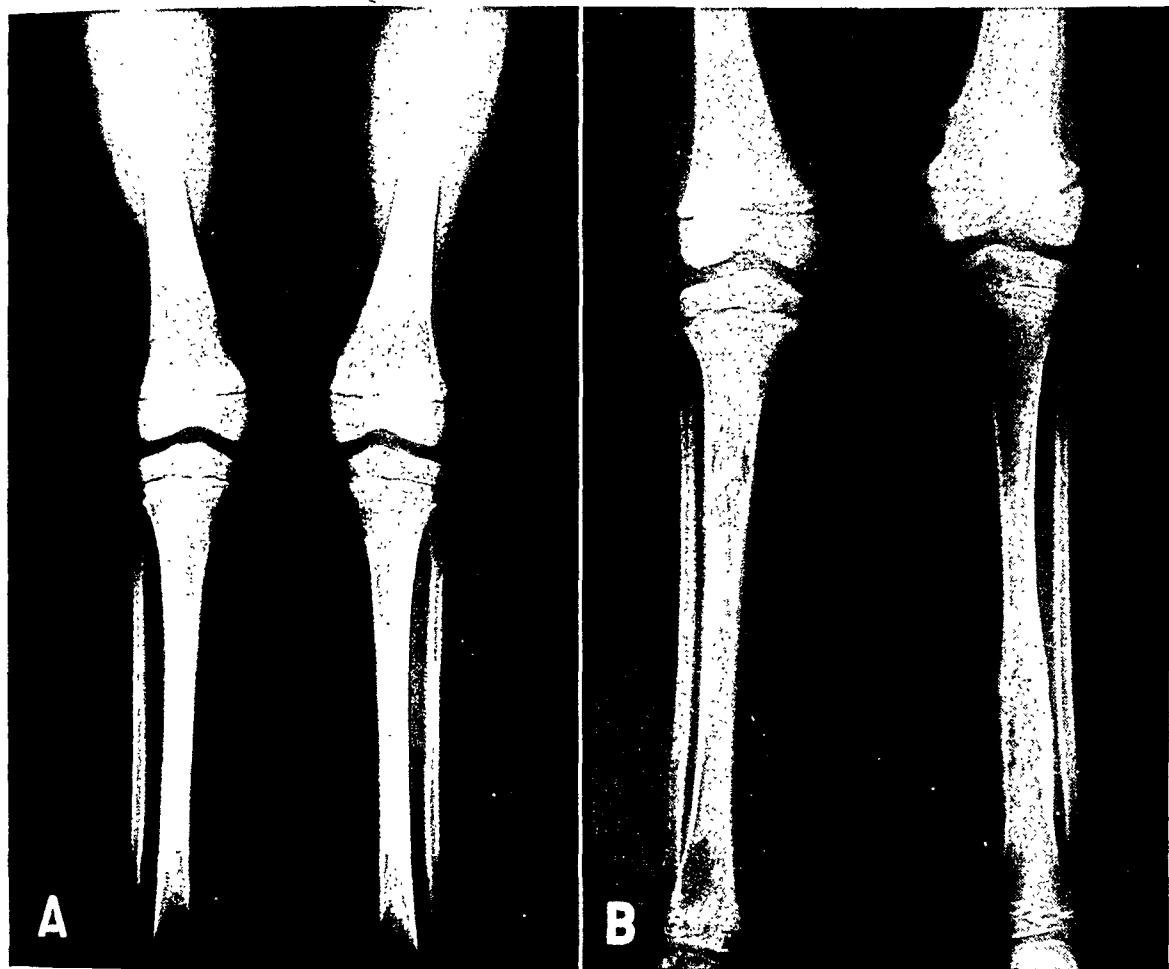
Case 5. A. Destructive lesions of the left femoral metaphysis (Jan. 16, 1940); the right ulna was similarly involved. In spite of adequate antisyphilitic treatment, the blood Wassermann reaction remained positive. B. Roentgenograms made Oct. 24, 1940, showing bone lesions to be more extensive and numerous. In several bones the epiphyses also became involved.
